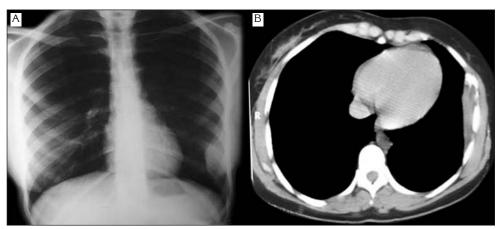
Chest X-ray showing left lung opacity (A) and CT scan showing mass lesion on the left anterolateral region of the sixth and seventh ribs (B).
